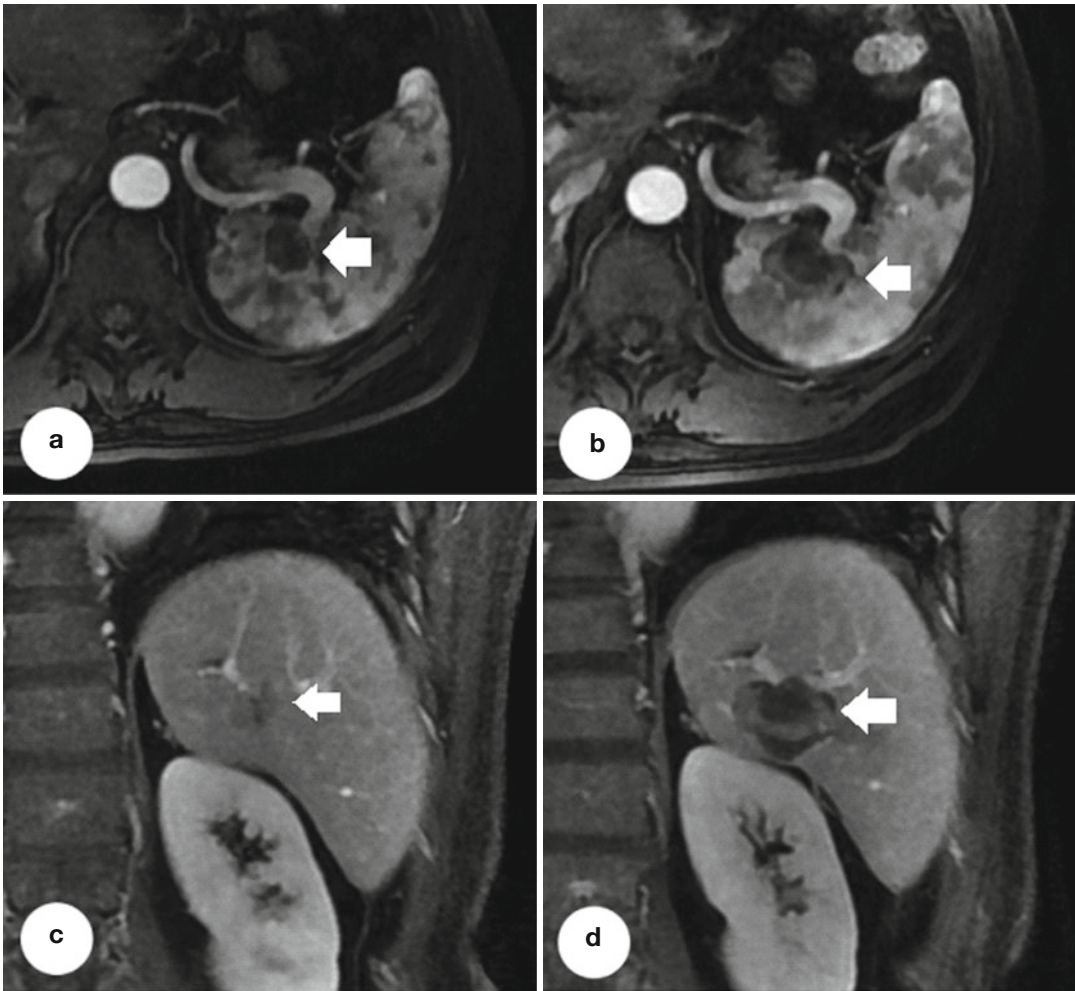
Transverse images and coronal images in a 58-year-old man with a single-focus (2.1×1.9 cm) colon cancer metastasis. Transverse contrast-enhanced magnetic resonance imaging (MRI) scan (a) and coronal contrast-enhanced MRI scan (c) before ablation show a
